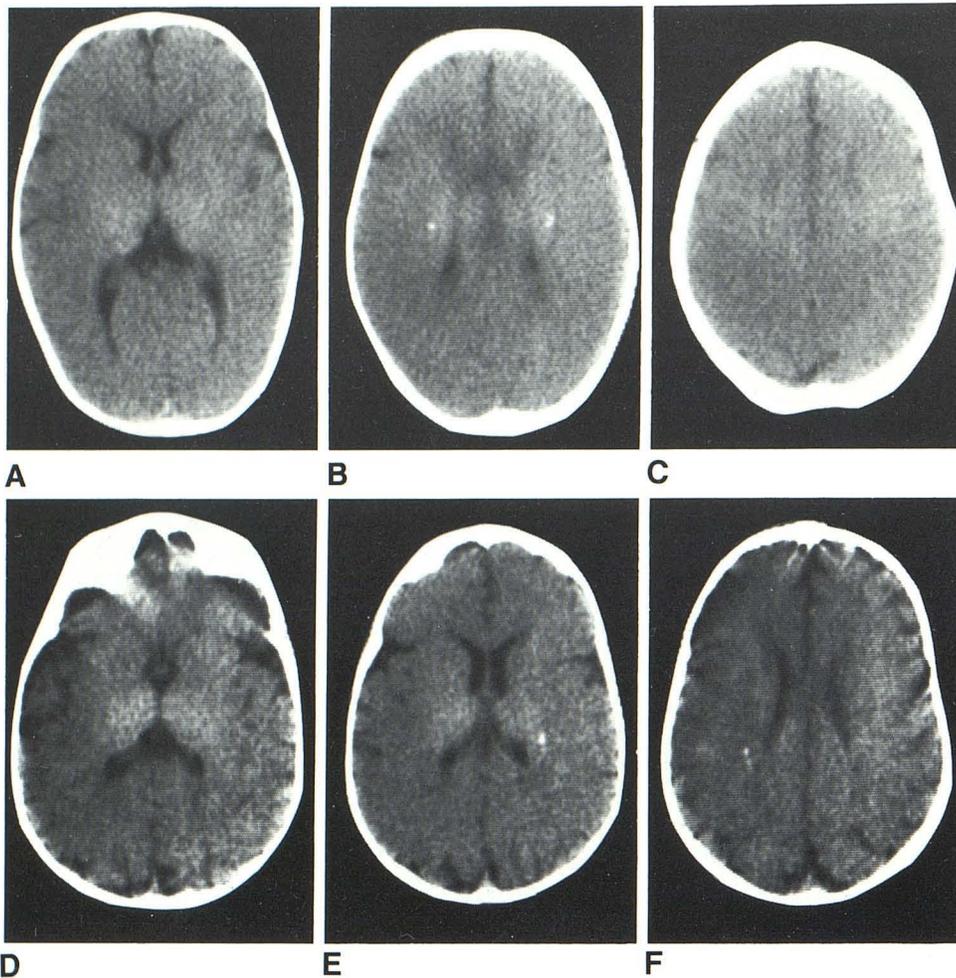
Case 1, 5-month-old boy with Krabbe disease. Nonenhanced CT scans. Symmetric increased density of thalami, body of caudate nuclei, and corona radiata (A and B). Symmetric punctate high density in corona radiata (B). Atrophy or demyelination not yet detected (C). D–F, 1 month later. Persistent increased density in thalami and new abnormal low attenuation along right corona radiata anteriorly (F).
